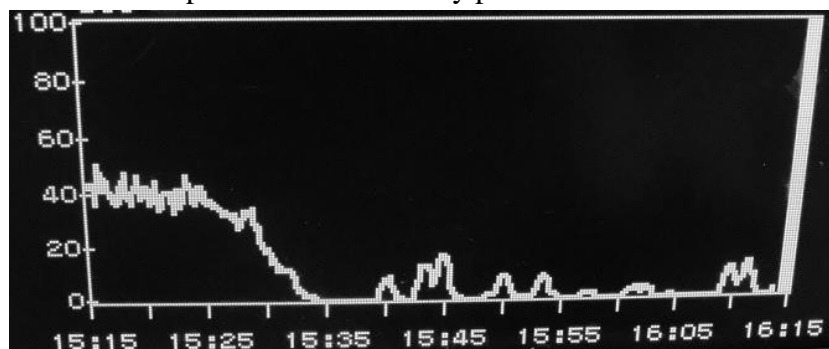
The velocity-time Doppler waveform of one of the patients.
